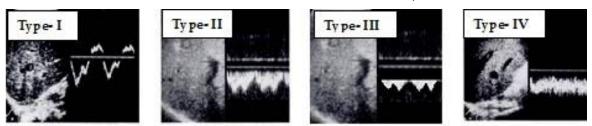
Hepatic vein doppler waveforms. Type-I: normal triphasic waveform, Type-II Biphasic without reduced oscillations, Type-III: Biphasic with reduced Oscillation and Type-I : Monophasic hepatic venous waveform.
